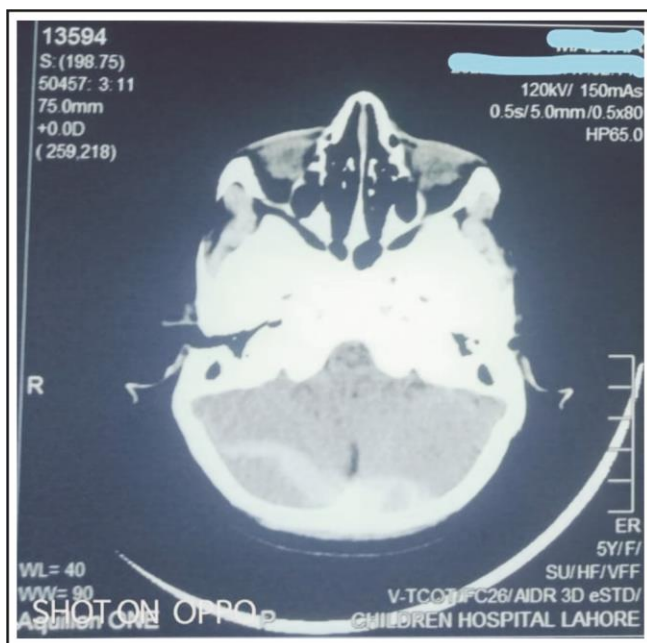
Plaintiff CT Brain with Bilateral PFEDH (Image was used after patient consent).
